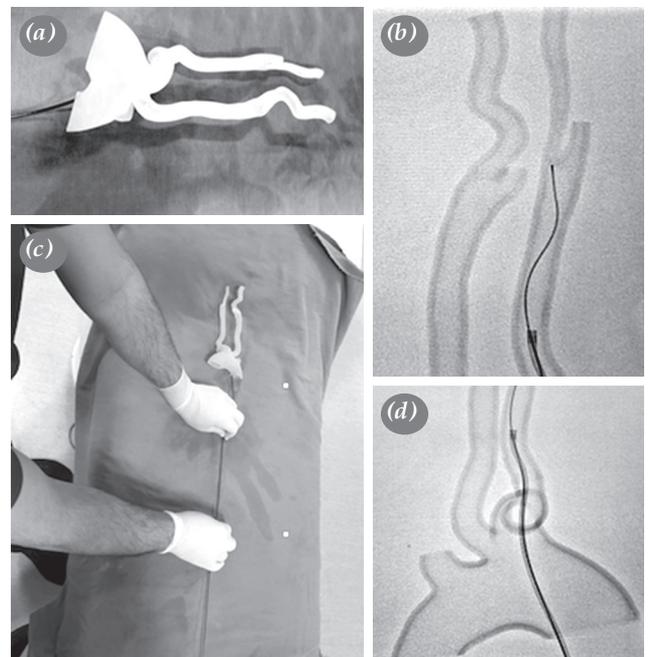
Manual practice with different catheters, wires on 3D physical models in both non-sterile environment and under X-ray tube. (a) Left common carotid artery cannulation with guiding catheter in non-sterile environment. (b) Cannulation of common carotid artery and crossing the internal carotid narrowing via guide wire under angiographic guidance in anteroposterior view. (c) Left internal carotid artery cannulation with guiding catheter in non-sterile environment. (d) Cannulation of common carotid artery and crossing the internal carotid narrowing via guide wire under angiographic guidance in lateral view.
